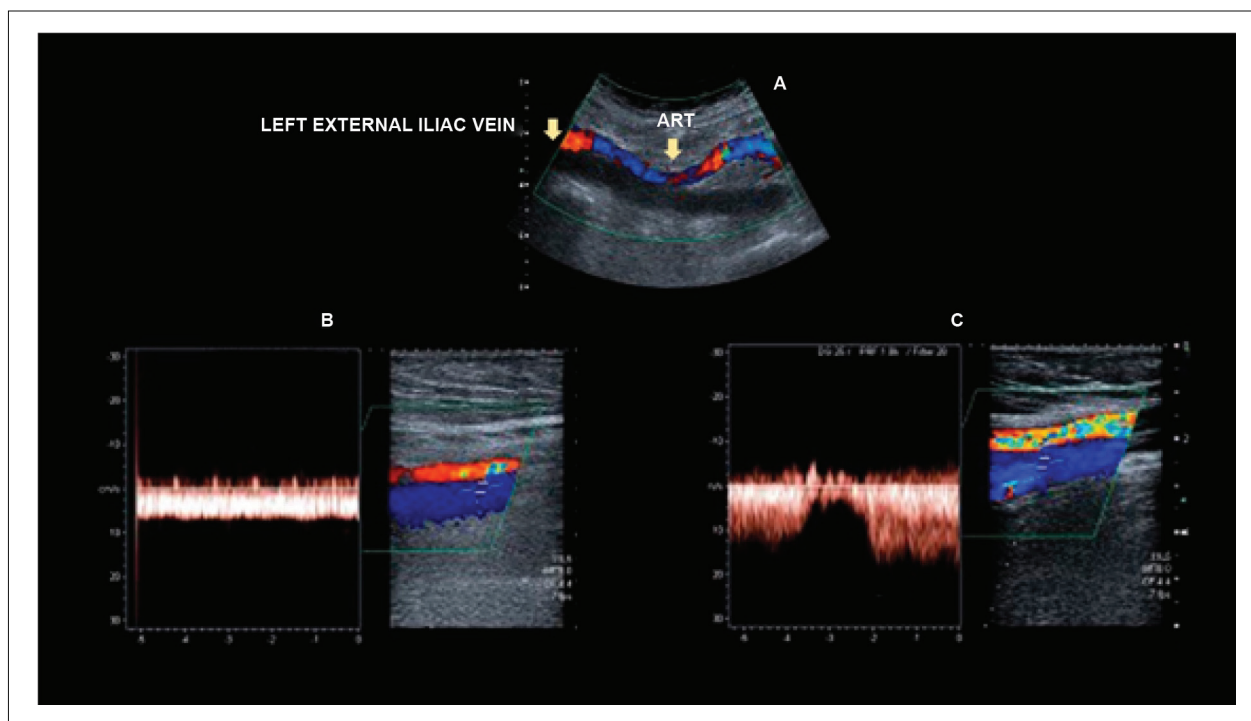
Left external iliac vein thrombosis: flow comparison between the left and right common femoral veins. A: color Doppler image showing no flow in the dilated left external iliac vein, with lumen filled with a thrombus of recent appearance; B: spectral Doppler image showing continuous flow in the common left femoral vein secondary to thrombosis of the ipsilateral external iliac vein; C: normal phasic flow in the contralateral common femoral vein.
